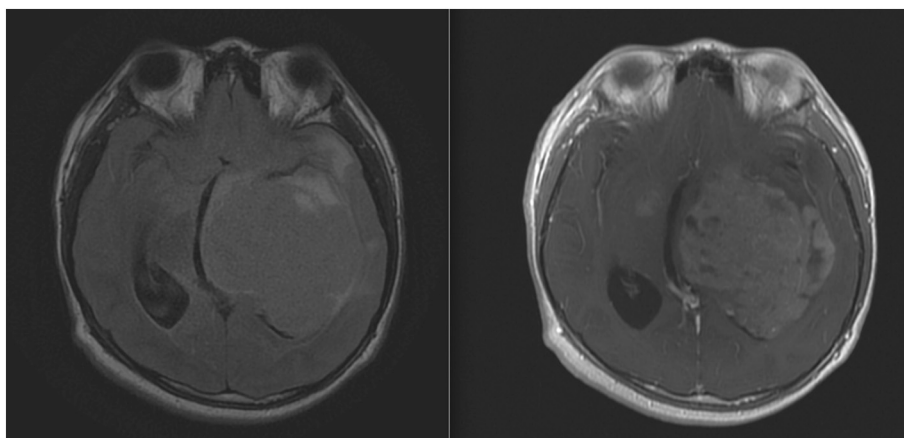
First MRI on September 2020, axial MRI with T2 (left) and T1 + contrast (right) sequence.
